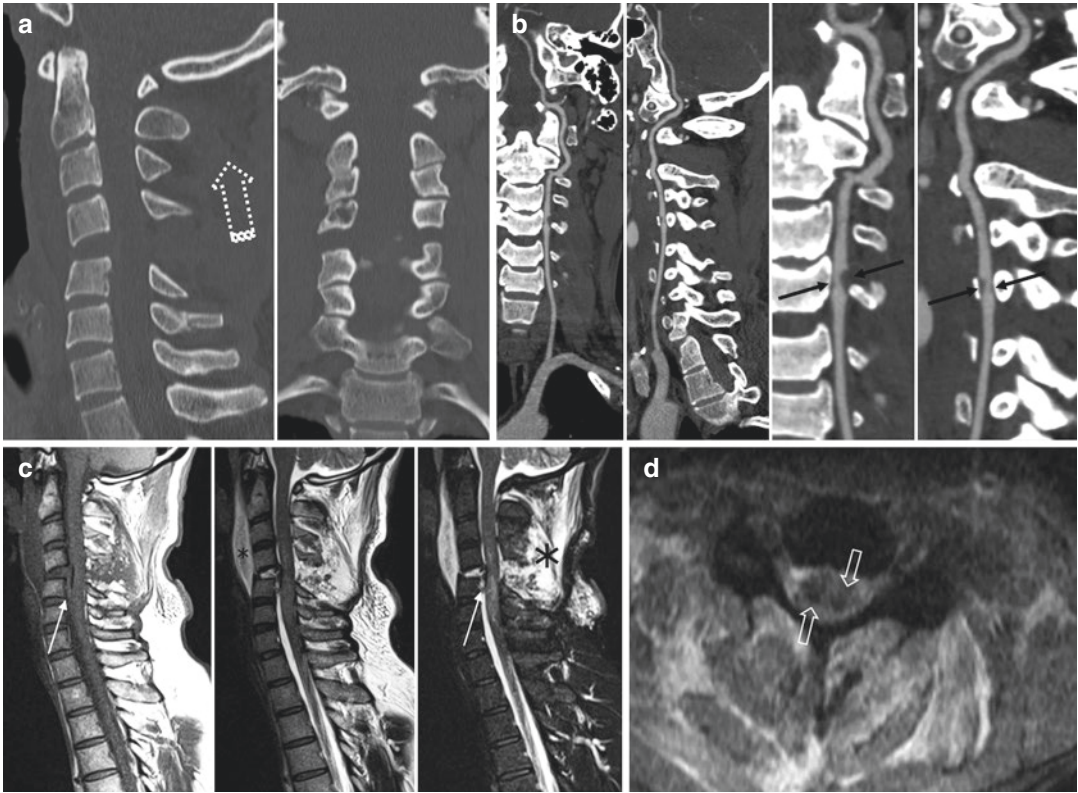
C4-C5 flexion distraction injury complicated by left vertebral artery dissection and hematomyelia: 2D-reformatted sagittal and coronal CT images (a), coronal and sagittal CT angiography images including magnification (b), T1- and T2-weighted, and STIR sagittal (c), and T2*-weighted axial (d) MR images. At C4-C5 level, the distraction injury mechanism (*open dashed arrow*) resulting in pure discal and ligamentous damage is clearly evident. CTA shows intimal flap (*black arrows*) of the left vertebral artery. MRI better shows an acute posttraumatic
